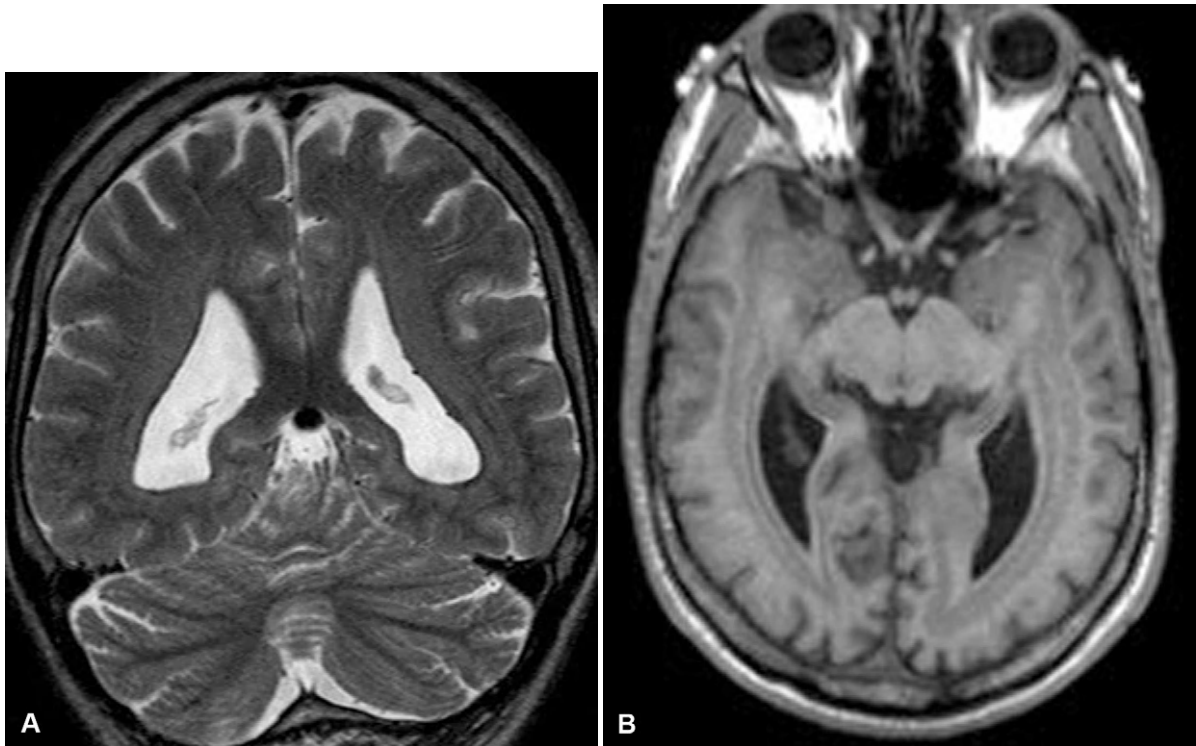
Band heterotopia: (A) T2-weighted and (B) inversion recovery images.
